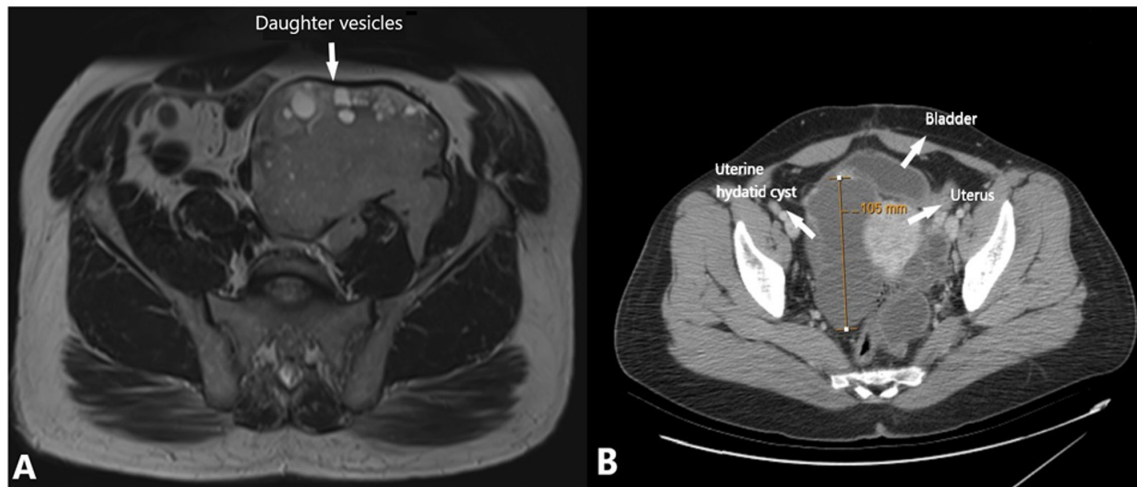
(A) MRI image of a hydatid cyst with daughter vesicles in the left retroperitoneum. (B) A 102 mm diameter multiseptate hydatid cyst was observed in the adnexal area in pelvic CT.
